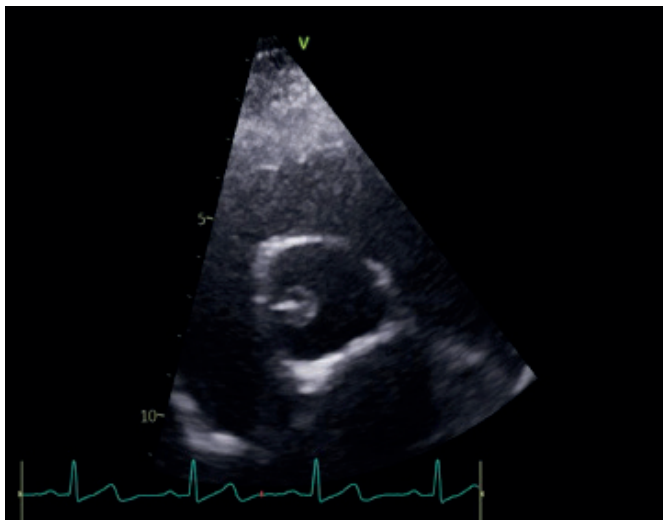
TTE Parasternal short-axis view, aortic valve level showing the mass which appears to be attached between the aortic valves right and non-coronary cusp.
